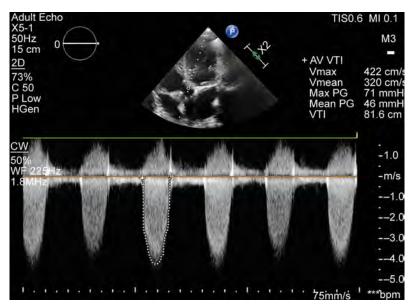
Continuous wave Doppler showing gradients across the valve, suggesting severe aortic stenosis
